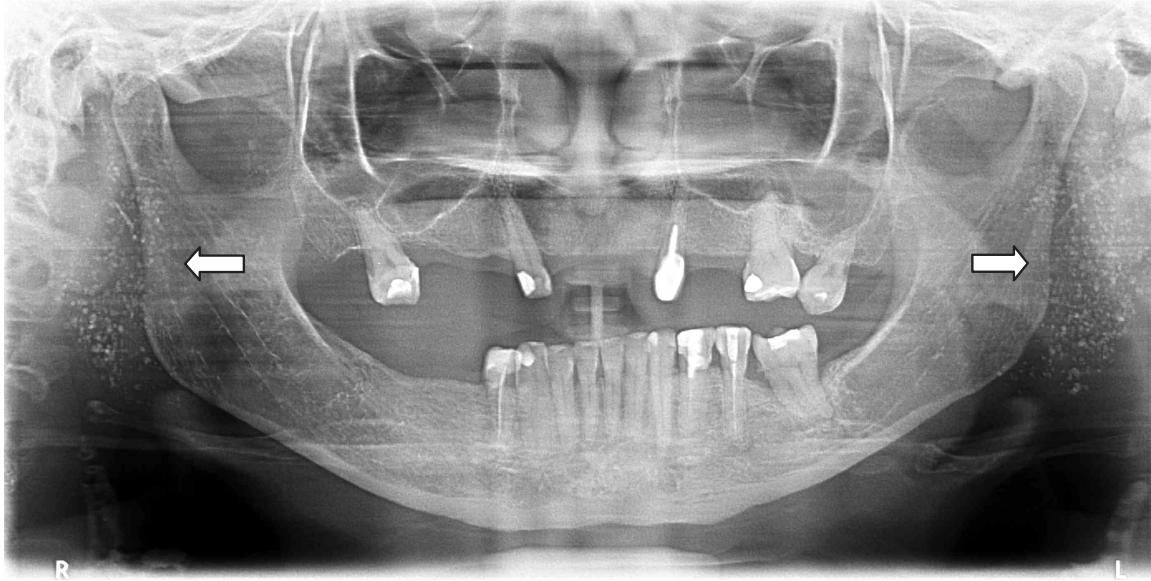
Digital panoramic radiography with image suggesting calcifications in the right submandibular and parotid glands.
